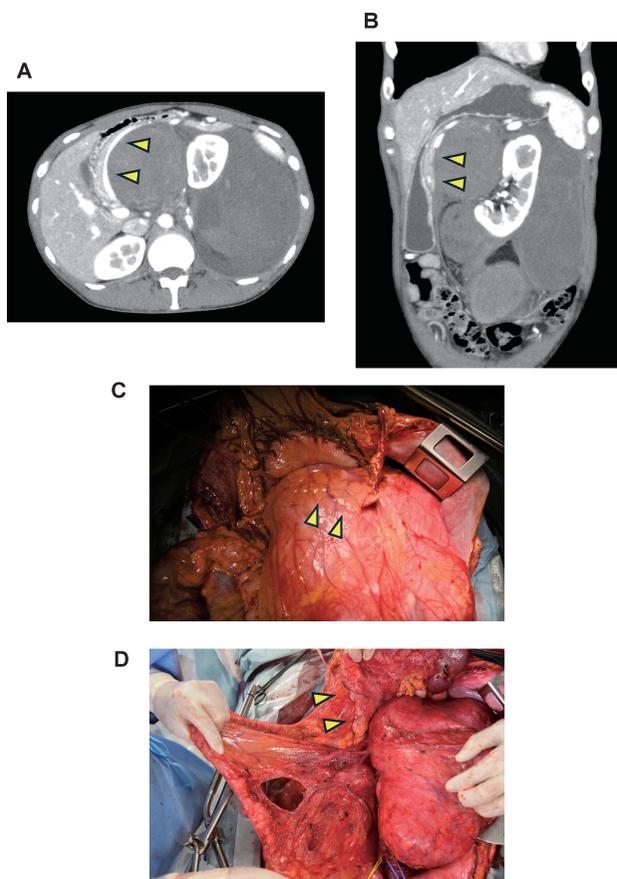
A case of a large left-sided retroperitoneal liposarcoma. Axial (A) and coronal (B) computed tomography images indicate that the tumor was in wide contact with the pancreatic body and tail (arrowheads). There was no invasion of the tumor into the pancreas, and it was separated from the tumor (C and D).
